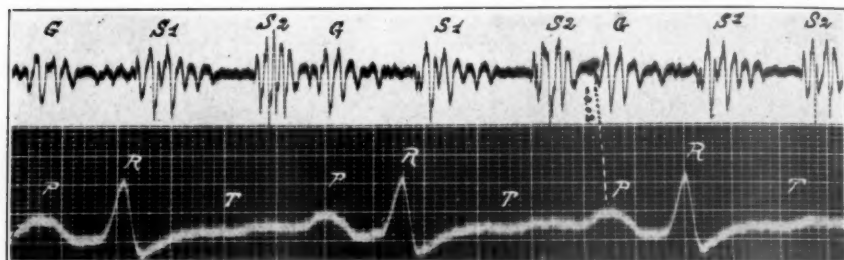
Myocarditis. Male, forty-eight years old, alcoholic, Wassermann negative. Blood urea 0.06 per cent. Albuminuria 0.05 per cent. X-ray examination showed the heart sensibly increased in size especially the left ventricle. Tracing taken June 8, 1931, during a serious attack of decompensation. Diastolic gallop rhythm. P-G interval 0.02 sec. decompensation.
